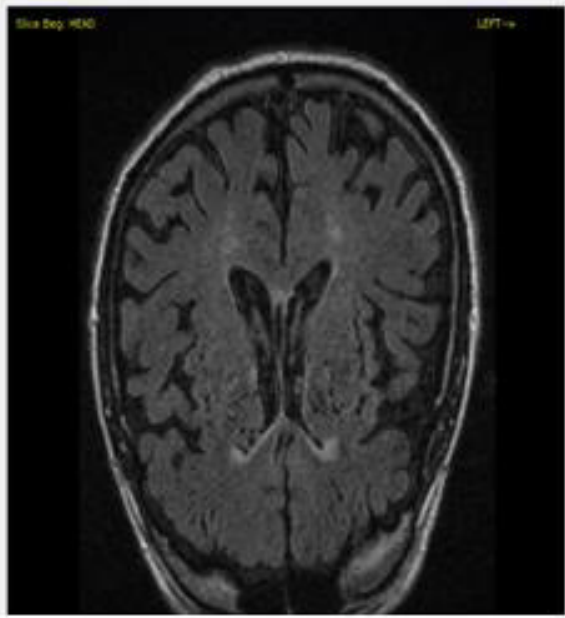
FLAIR Image of MRI scan of a patient with enlarged Virchow-Robin Spaces. Such a high presence is abnormal.
